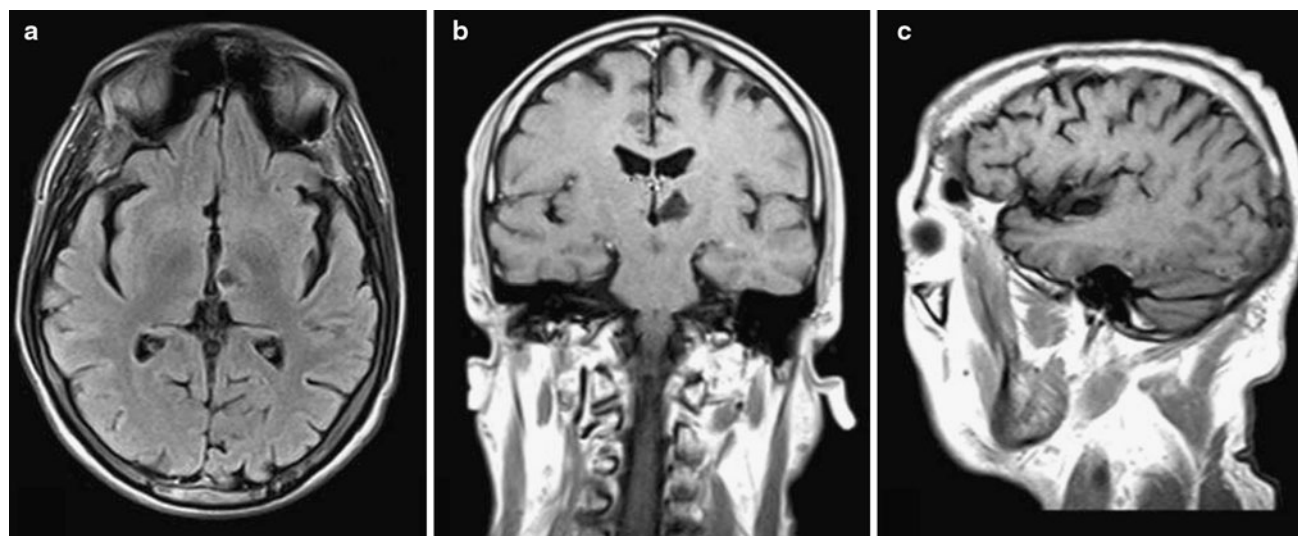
Brain MRI: axial (a) fluid attenuated inversion recovery (FLAIR) and coronal (b) T1-weighted scans showed the ischemic lesion in the left paramedian thalamic nuclei; sagittal (c) T1-weighted image showed mild frontotemporal atrophy
